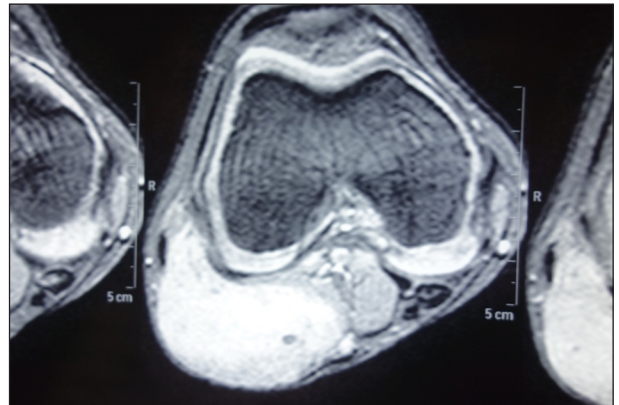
MRI of the popliteal fossa swelling suggesting a 7 x 4.6 x 3.3 cm hyperintense soft tissue lesion with homogenous enhancement, which increased during venous phase suggesting neoplastic etiology.
